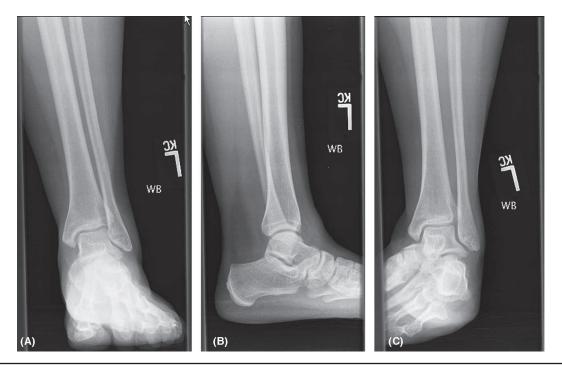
Normal ankle radiographs, no syndesmotic disruption.
